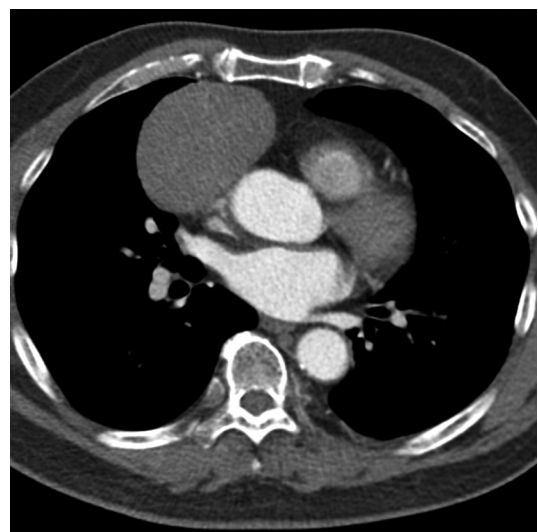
Thymic carcinoid. Contrast-enhanced axial CT demonstrates a homogenous right prevascular mediastinal mass abutting the pericardium. Atypical carcinoid tumor was confirmed after surgery.
